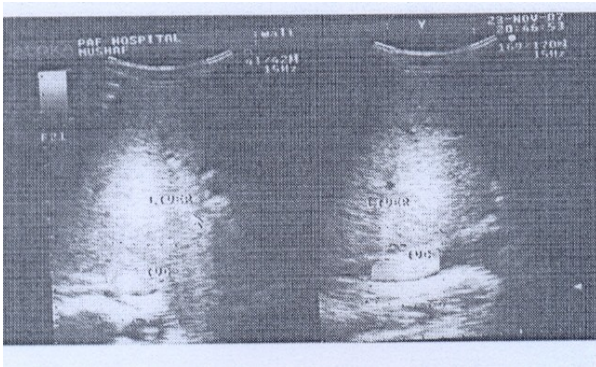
Color doppler ultrasonography thrombus
